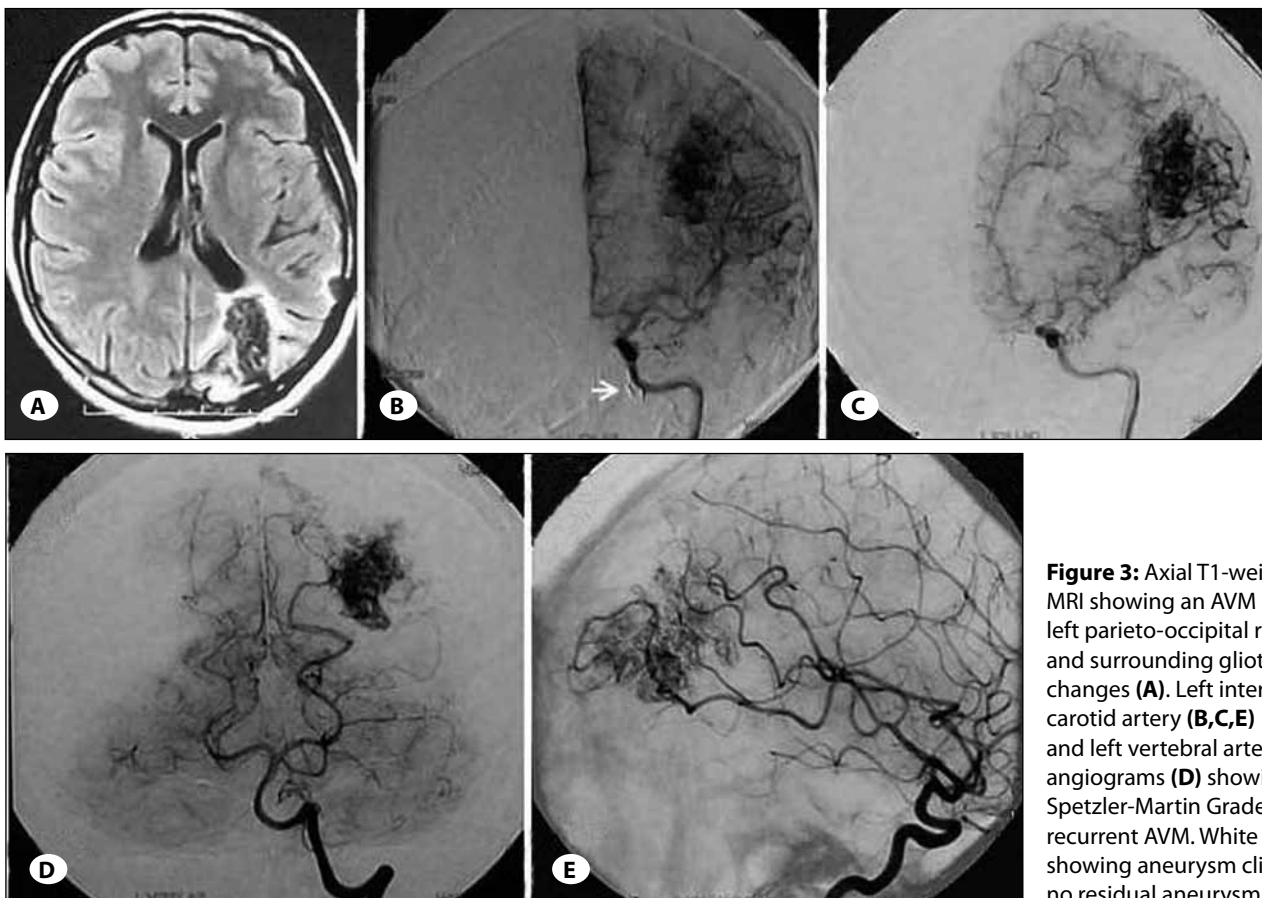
Axial T1-weighted MRI showing an AVM on the left parieto-occipital region and surrounding gliotic changes (A). Left internal carotid artery (B,C,E) and left vertebral artery angiograms (D) showing Spetzler-Martin Grade III recurrent AVM. White arrow showing aneurysm clip and no residual aneurysm (B).
